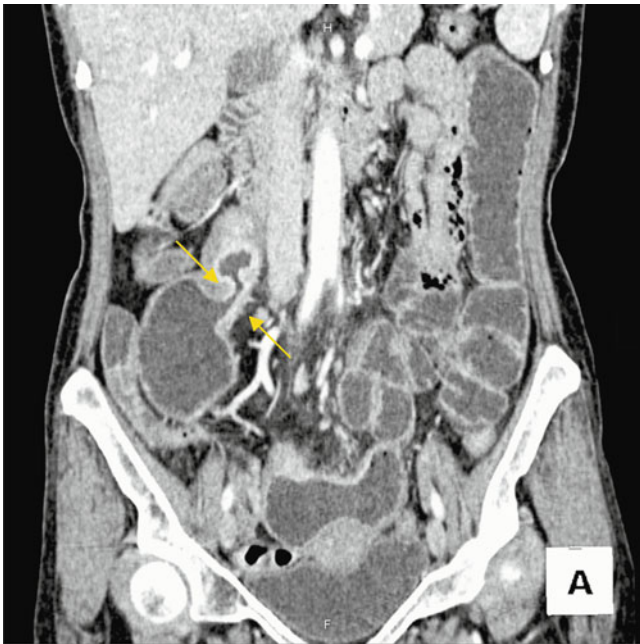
Abdominal CT MPR image. MPR image of a patient with Crohn's disease and intestinal obstruction. The small intestine is visualized to a comparatively wide extent due to the backing up of intestinal fluid. Stenosis of the ileum is evident, with thickening of the intestinal wall, and the intestinal tract is dilated on the proximal side. This was regarded as the culprit lesion
